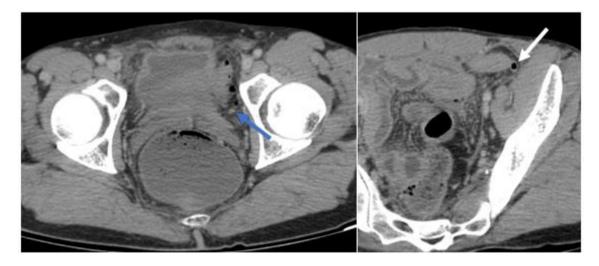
A and 2B: CT scan image showing a multiple sigmoidal diverticula (white arrow), with one of them is perforated and facing pneumoperitoneum bubbles (blue arrow)
